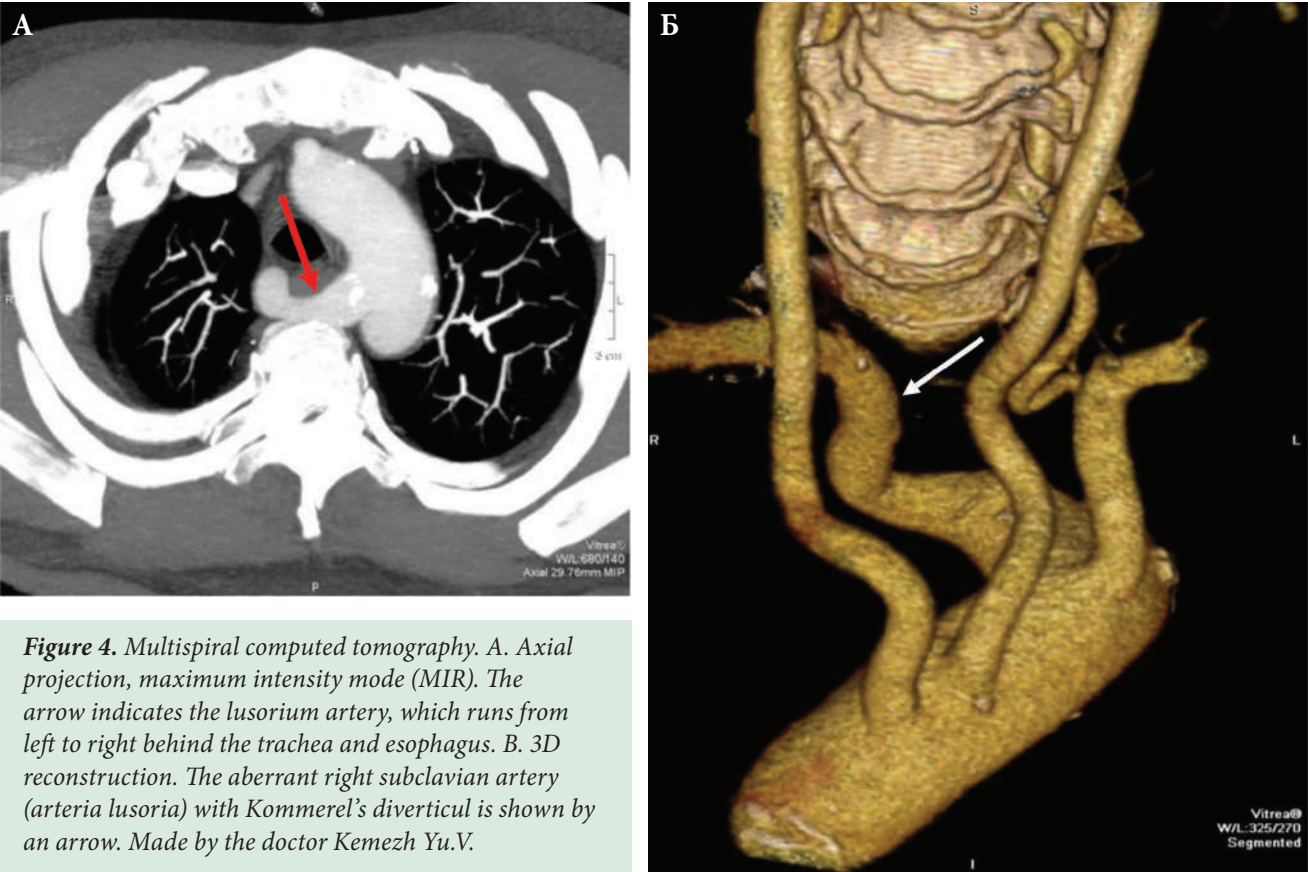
Multispiral computed tomography. A. Axial projection, maximum intensity mode (MIR). The arrow indicates the lusorium artery, which runs from left to right behind the trachea and esophagus. B. 3D reconstruction. The aberrant right subclavian artery (arteria lusoria) with Kommerel's diverticul is shown by an arrow. Made by the doctor Kemezh Yu.V.
